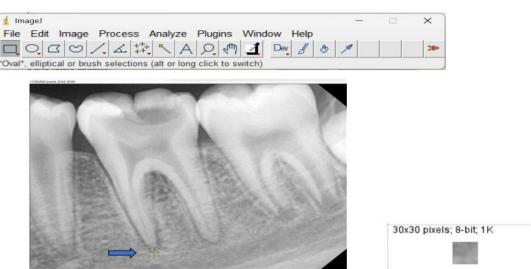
Periapical radiograph, ImageJ Cropping the blue arrow ROI area
